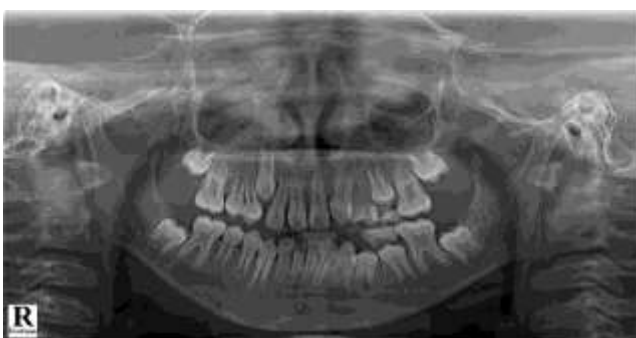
Panoramic radiograph of a patient with supernumerary tooth in maxillary anterior region
